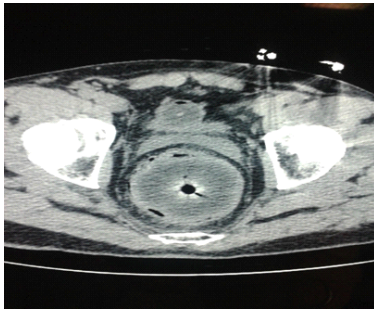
CT aspect of a rectal apple.
